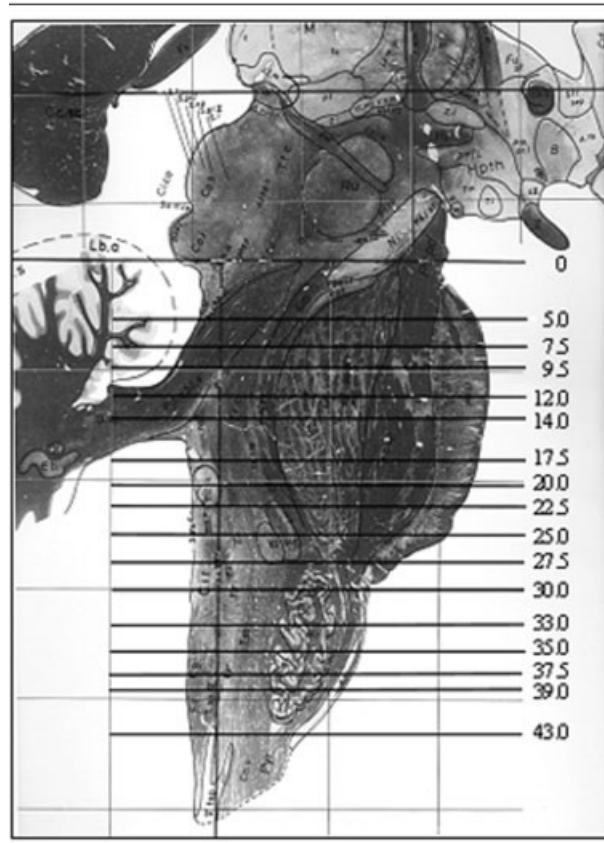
Sagittal view of the brainstem according to the anatomical atlas of Schaltenbrand and Wahren.²¹ Orientation of magnetic resonance imaging scans was done parallel and perpendicular to the axial slices shown. Numbers represent the distance from the pontomesencephalic junction (zero point) in millimeters in craniocaudal direction.
